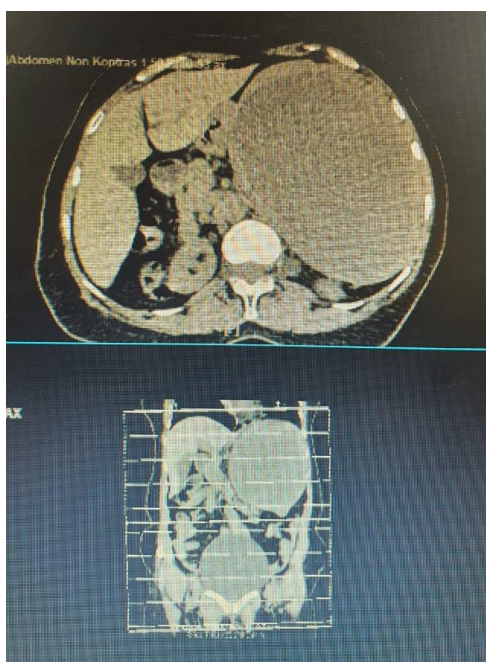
CT scan of the abdomen and pelvic without contrast.
